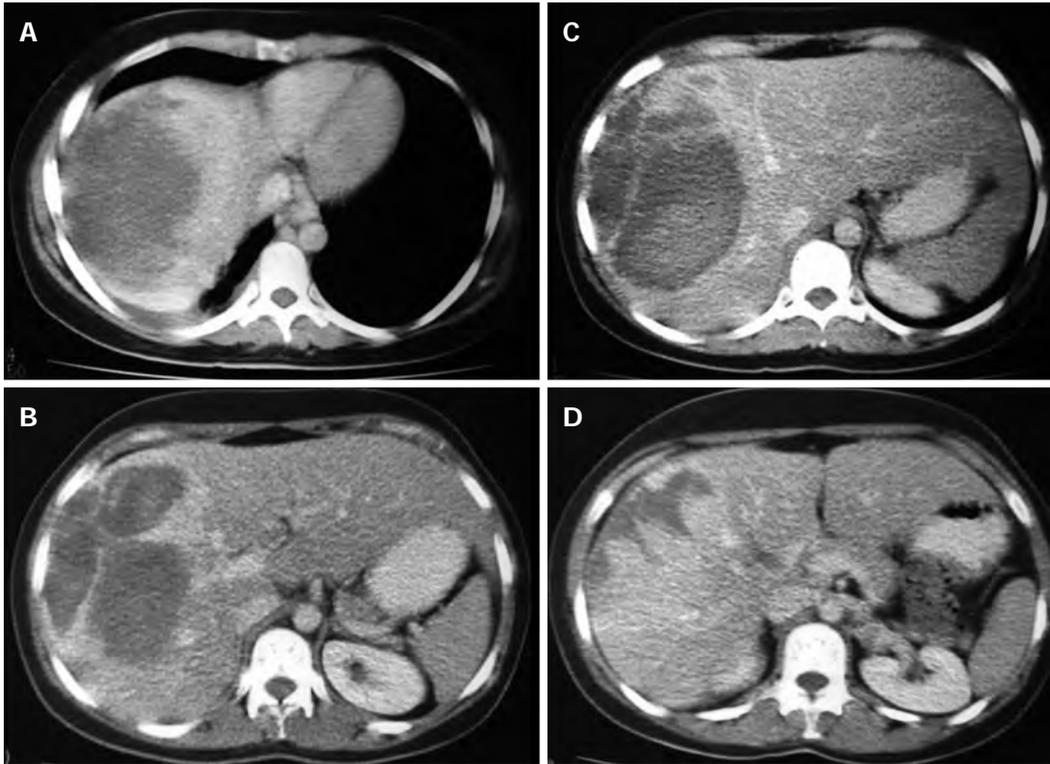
Unenhanced computed tomography scan showing liver injury with bleeding area, but also with areas of contrast enhancement. A-D: The existence of bleeding denotes a hepatic laceration, but the presence of vascularization reinforces the presence of a focal lesion.
